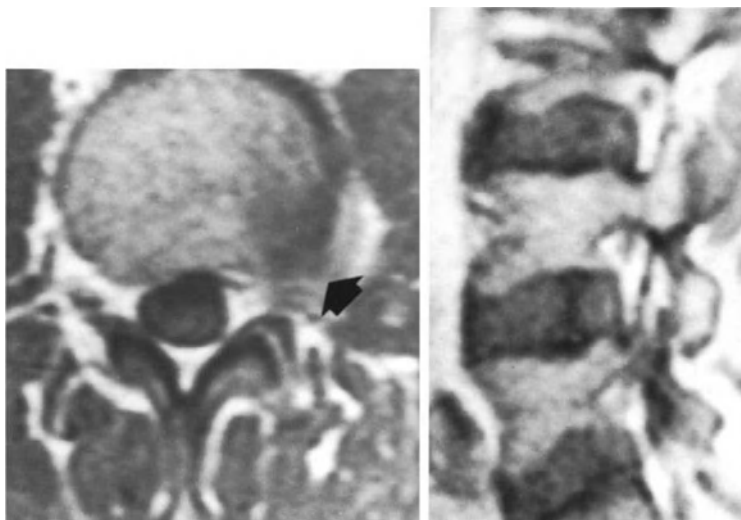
L3-L4 extraforaminal disc herniation on the left. The spin-echo T1-weighted axial image shows a focal convexity of the left lateral margin of the disc and obliteration of the paravertebral fat tissue (arrow). The spin-echo T1-weighted sagittal section through the intervertebral foramen does not show the disc herniation, since this is extraforaminal.
